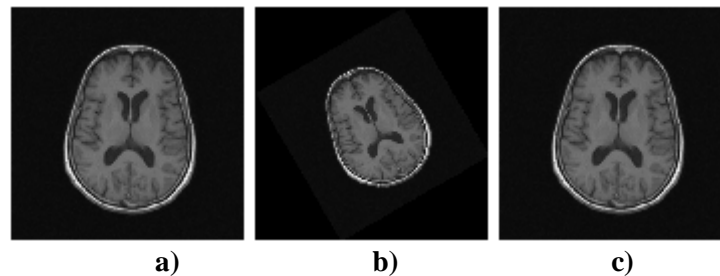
landmark based registration applied to MRI slice. a) reference image, b) target image, c) registered image
